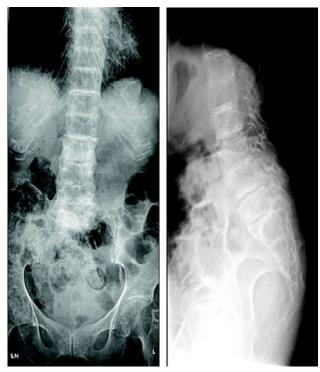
X-rays showing calcification of intervertebral discs, reduced joint space, and reactive sclerosis.
